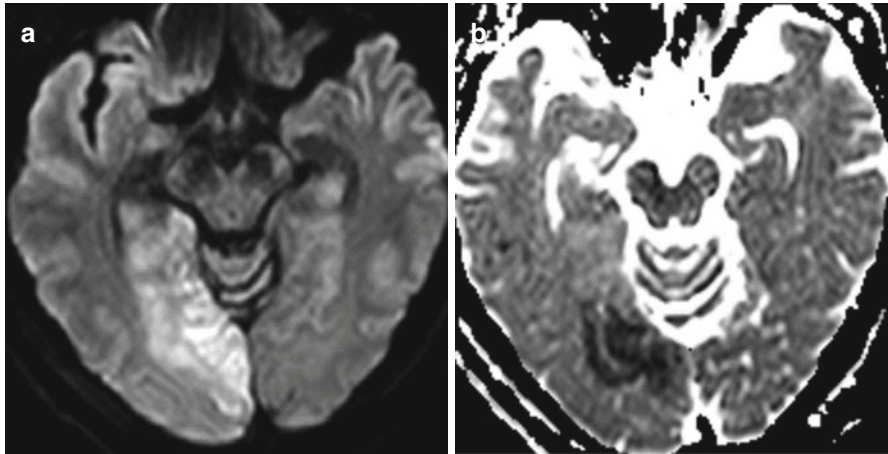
(a, b) Hyperacute infarction in the right PCA territory. Diffusion-weighted MR image (a) and ADC map (b) show the area of restricted diffusion due to cytotoxic oedema
